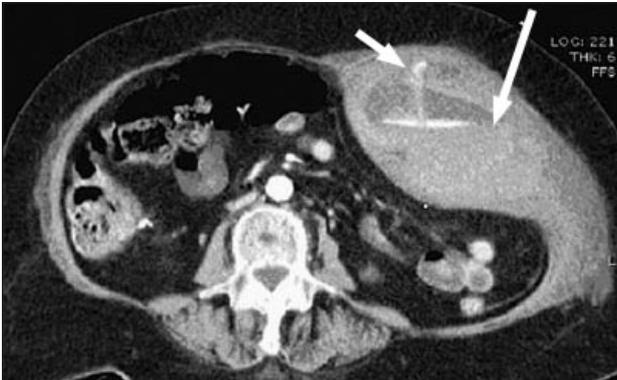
Trauma to the anterior abdominal wall. Axial computed tomography scan shows a large left rectus muscle haematoma (long arrow) with vascular contrast material extravasation (short arrow), indicating active haemorrhage.
